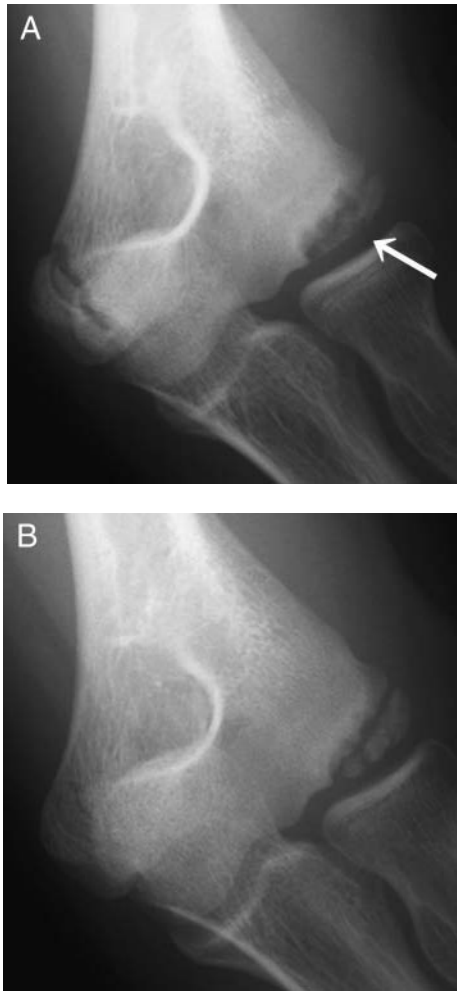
A-16-year-old baseball player with an advanced stage of osteochondritis dissecans. A, AP view with elbow in 45° of flexion at initial examination, demonstrating typical fragments demarcated by sclerosis (arrow). B, after 12 months, radiograph shows nonhealed lesion.
